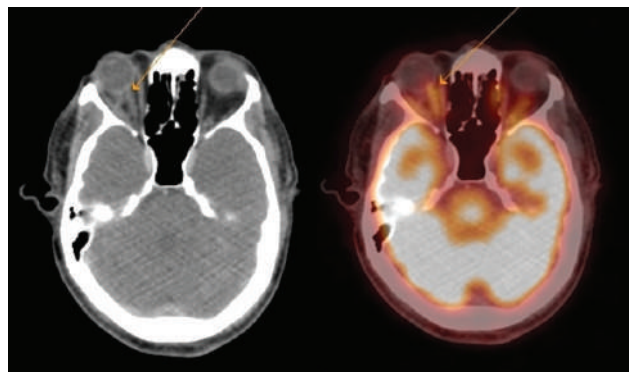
After chemotherapy, the PET-CT showed almost complete remission of the lesion, with adjacent fat stranding area.
